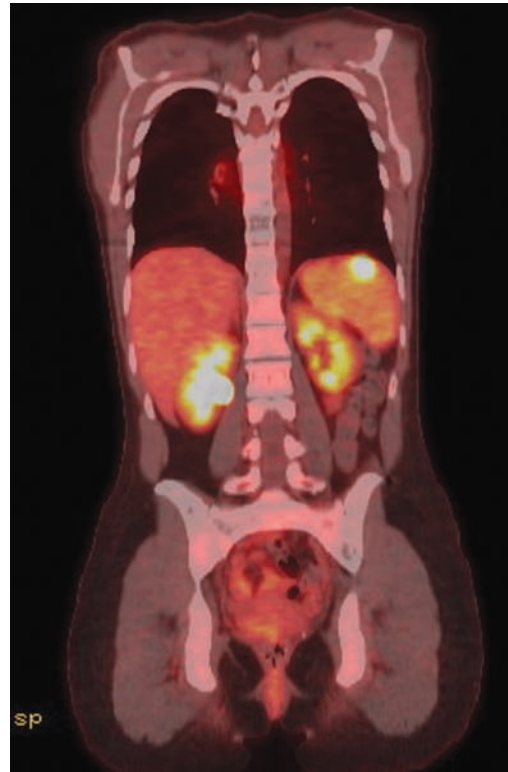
The patient was found to have a splenic lesion on CT which was active on PET scan. She subsequently underwent a splenectomy to obtain a tissue diagnosis.
